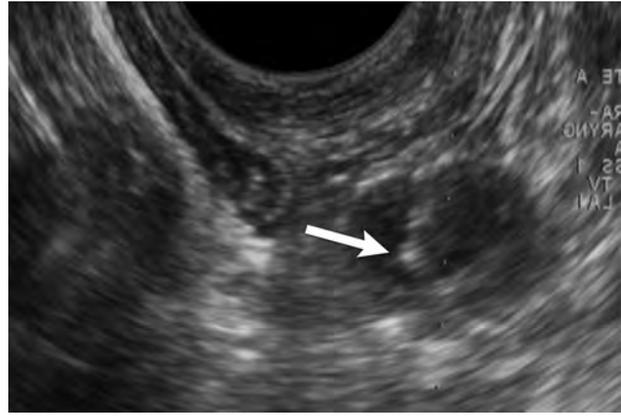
Needle tip visualization. Transverse sonography during biopsy of a left retropharyngeal lesion demonstrates the needle and needle tip (white arrow) accurately placed within the lesion.
